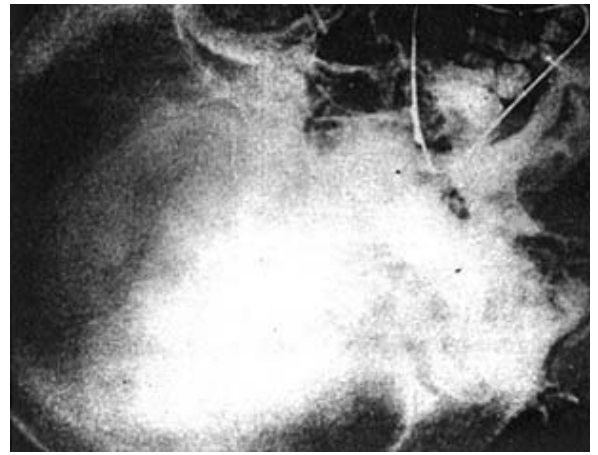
X-rays showing the wire.
